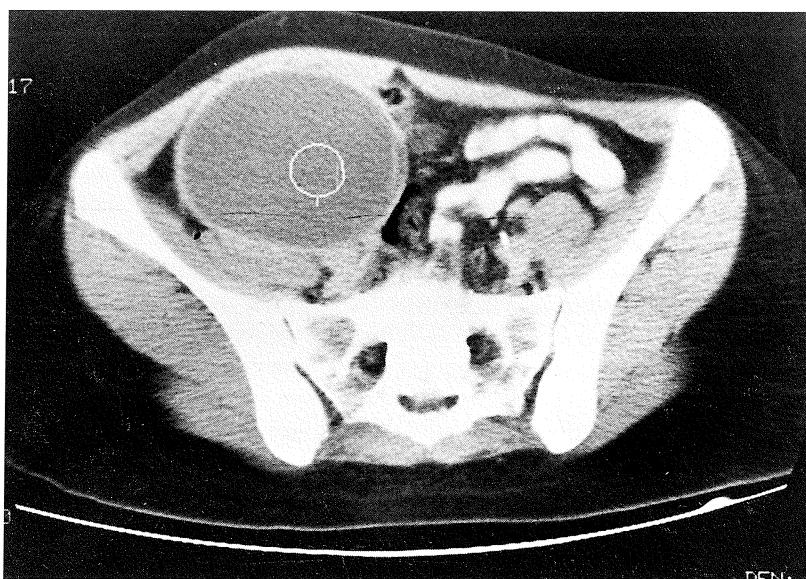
CT scan examination of the upper section of the huge retroperitoneal cyst.
